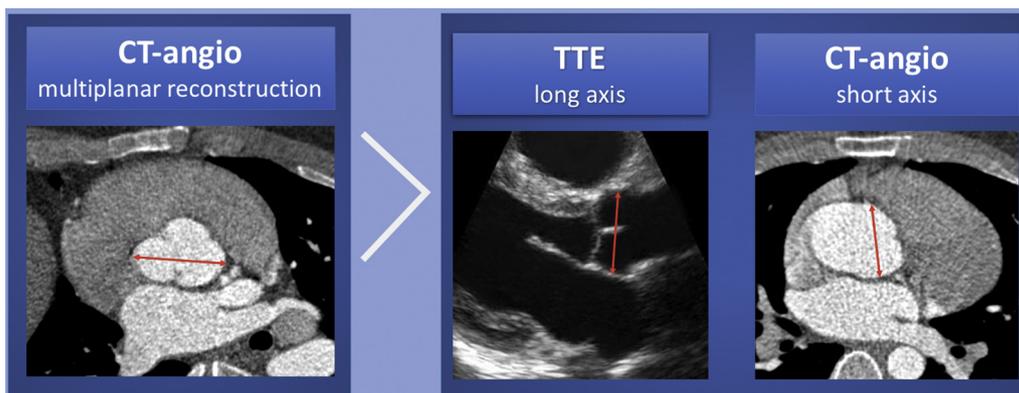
Underestimation of aortic root dimensions based on the method of the measurement. *CT*, Computed tomography; *TTE*, transthoracic echocardiography.
